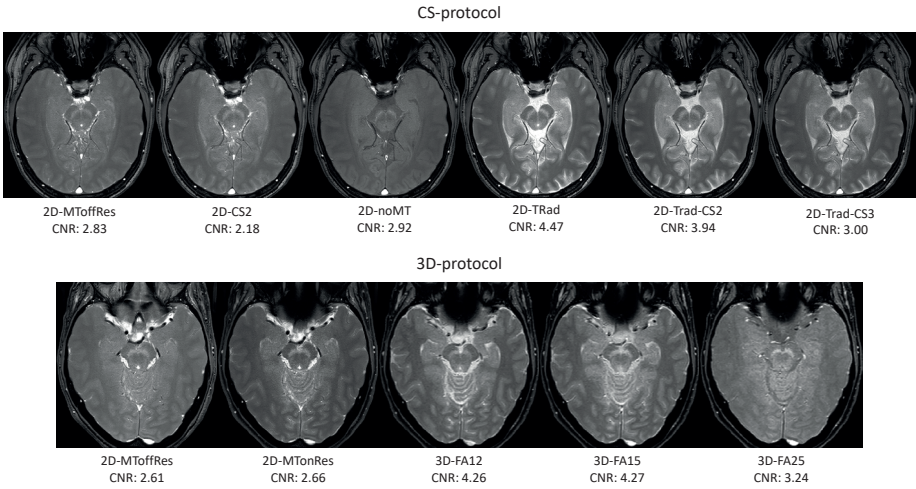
Overview of the NM-MRI scans. An example of the NM-MRI sequences of one participant of the CS protocol and one participant of the 3D protocol, with the mean contrast to noise ratio (CNR) of all participants per scan. MT, magnetization transfer; Res, resonance; CS, compressed sense; TRad, repetition time adjusted; FA, flip angle
